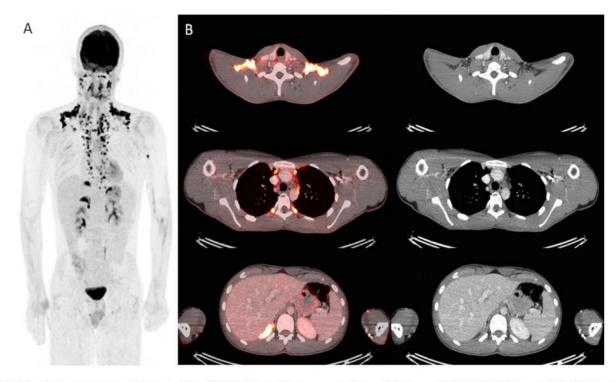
Maximum-intensity projection (MIP) (A) and transverse slices of fusion of FDG-PET/CT and CT (B) demonstrating physiological high FDG-uptake in brown fat in cervical, paraclavicular, paravertebral, mediastinal, parasternal, retrocrural and pararenal regions in a 17-year old male patient with suspicion of lymphoma due to eosinophylic fasciitis. No lesions suspicious of lymphoma were diagnosed on FDG-PET/CT.
